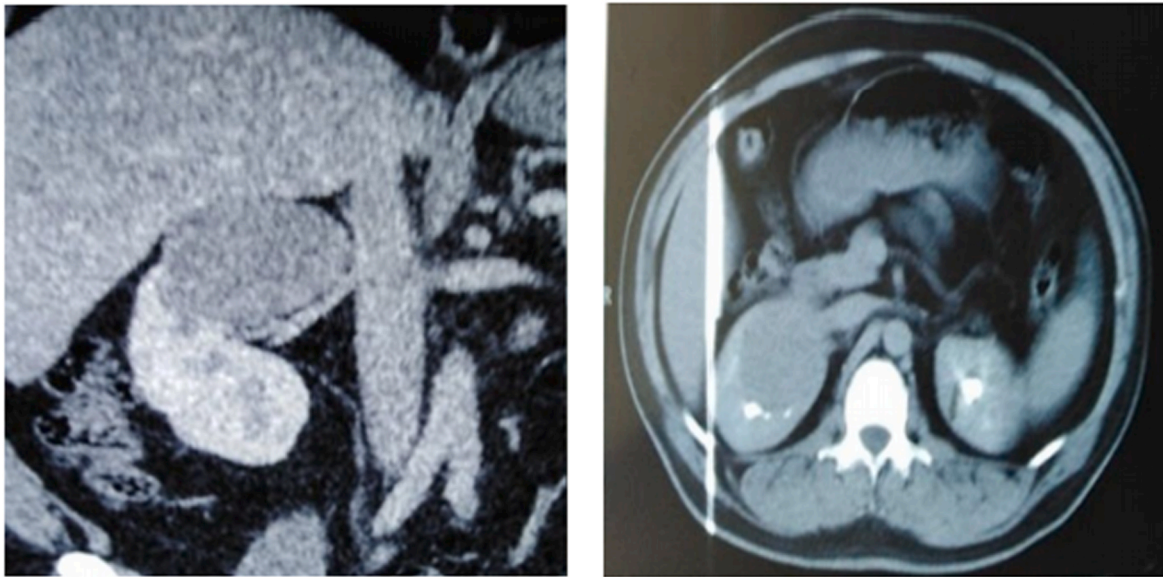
A,1B: Contrast enhanced abdominal CT scan. It revealed a tumor on the superior pole of the kidney.
